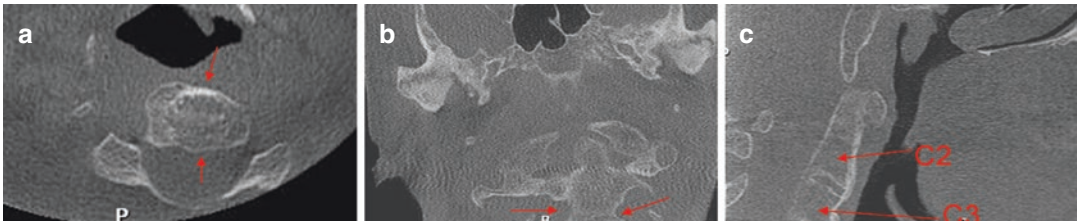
Axial (a), coronal (b), and midsagittal (c) CBCT image of an 11-year-old girl with a central hyperattenuated ossification spot corresponding with the subdental synchondrosis clearly visible almost 3 years after complete ossification
